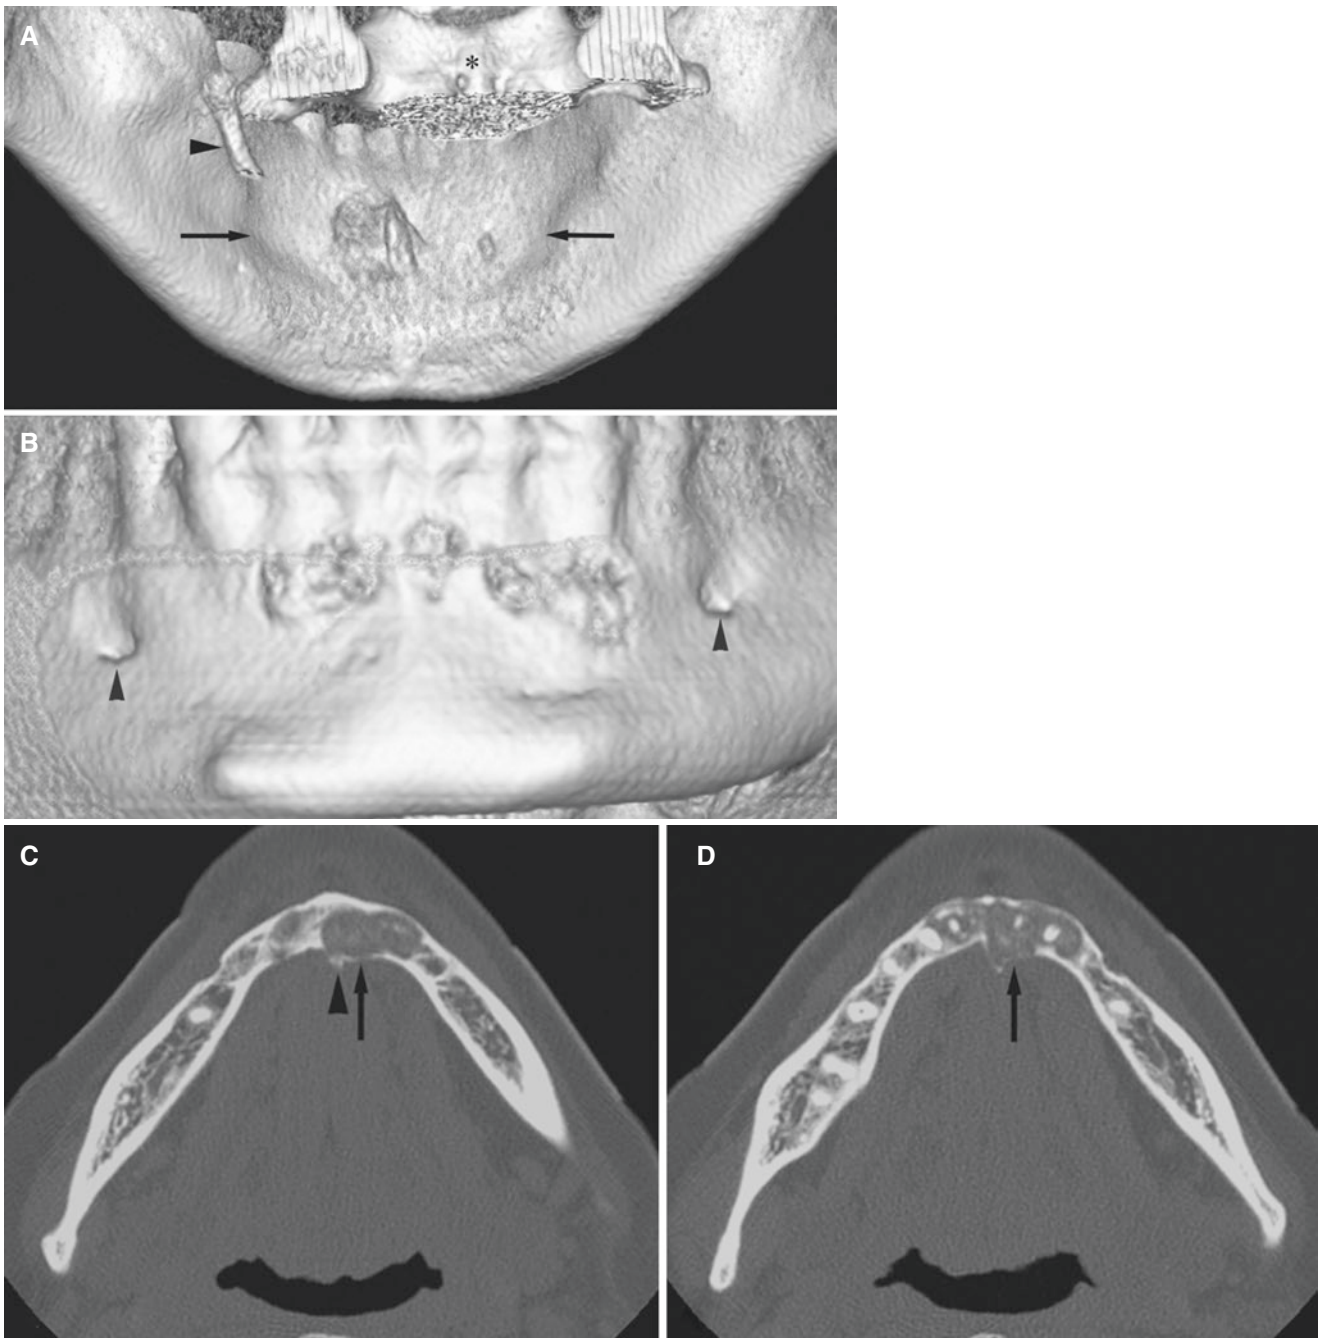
Ossifying fibroma, mandible; 41-year-old female with painless swelling of lingual aspect of anterior mandible. (A) 3D CT image shows swelling on lingual side with cortical defects (*arrows*). Note the styloid process (*arrowhead*) and cervical spine (*asterisk*). (B) 3D CT image shows cortical defects on buccal side between mental foramina (*arrowheads*). (C) Axial CT image shows well-defined radiolucency with some expansion and intact cortical bone lingually (*arrow*). Note lingual crista (*arrowhead*) and small mineralizations. (D) Axial CT
